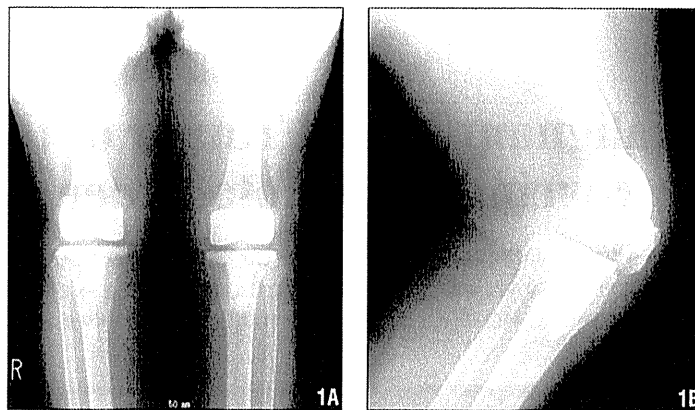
Anteroposterior (A) and lateral (B) radiographs did not show the tumor at the lateral side of the implant of the left knee.
